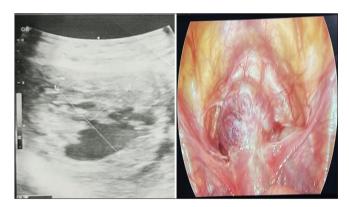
Representation of scar ectopic through Ultrasonography film (Left) and Laparoscopic view of peritonium (Right)
